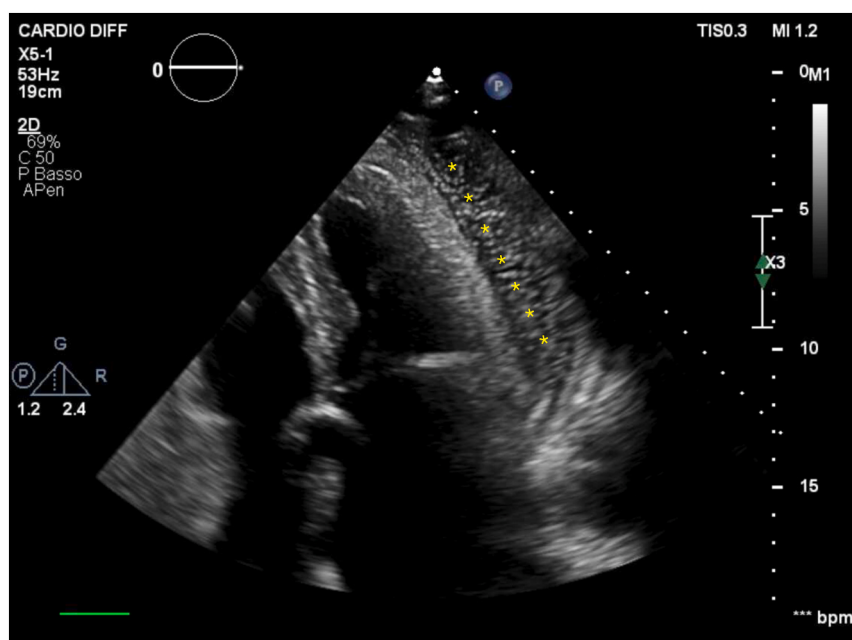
Off-axis four-chamber echocardiographic view showing air bubbles (asterisks) within the fluid in the pericardial space, evident laterally to the left ventricle.
